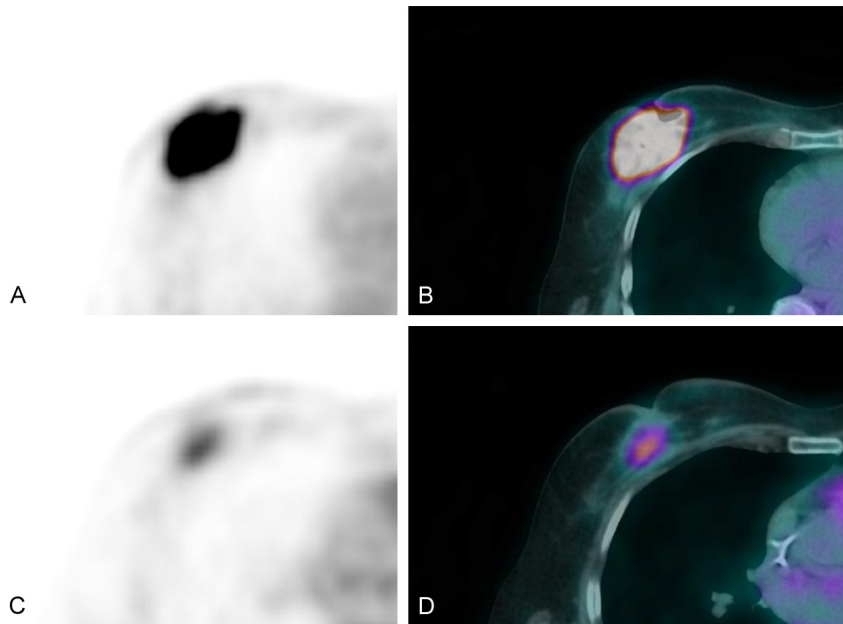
Early interim FDG PET/CT response in a 53-year-old woman with triple-negative breast cancer (80-mm grade 3 invasive ductal carcinoma of the right breast; T4N1M0, stage IIIB). A, B. Transaxial PET and fused PET/CT at baseline, showing an intensely FDG-avid primary tumor ($SUV_{max} = 23.3$). C, D. Corresponding images after two cycles of neoadjuvant chemotherapy, with markedly reduced residual uptake ($SUV_{max} = 3.7$; $\Delta SUV = -84\%$). The patient completed chemotherapy (two additional cycles of epirubicin [75 mg/m²] plus cyclophosphamide [750 mg/m²], followed by four cycles of docetaxel [100 mg/m²]) and achieved a pathologic complete response at mastectomy, with no residual invasive tumor in the breast and nine tumor-negative axillary lymph nodes. Reproduced with permission from Groheux D, et al. *J Nucl Med* 2012; 53(2): 249-254. © SNMMI [54].
